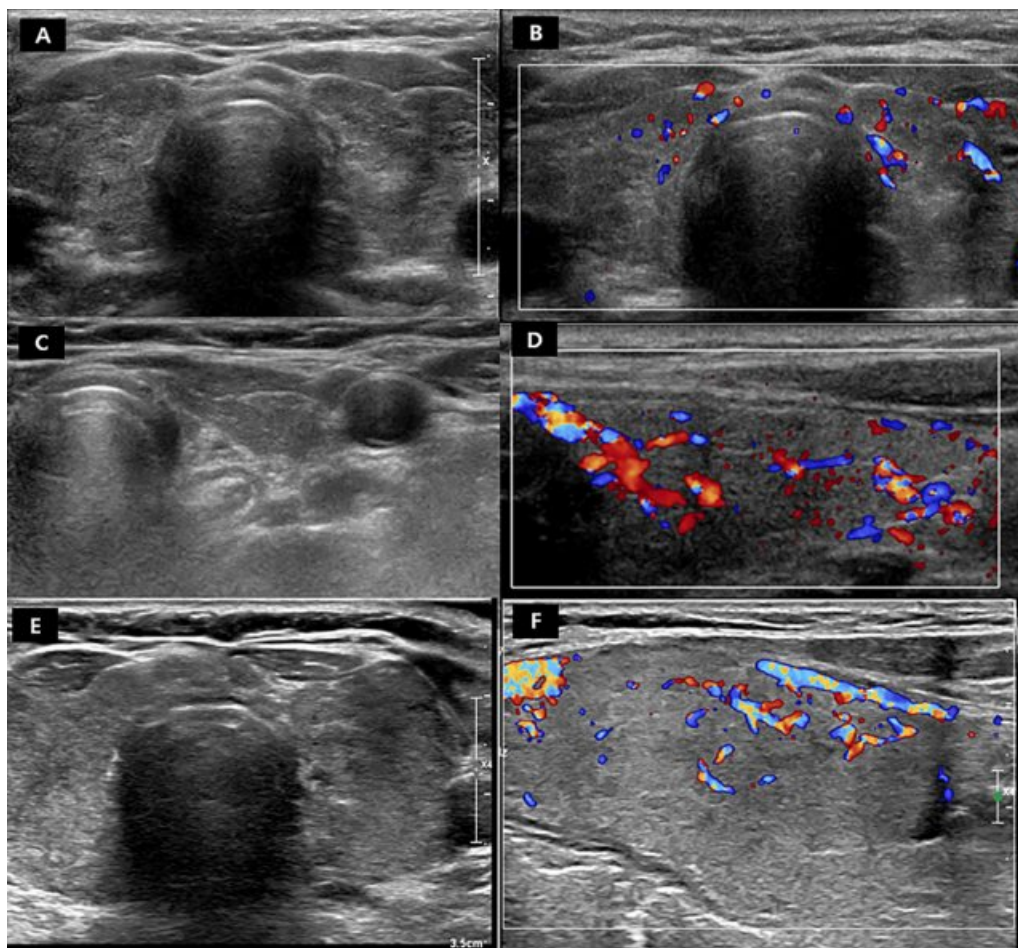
Examples of US features of diffuse thyroid disease (DTD) in three participants. (A, B) US images in a 42-year-old female participant with DTD. (A) Transverse gray-scale image shows heterogeneous coarse echotexture with decreased parenchymal echo and normal anteroposterior diameter. The glandular margin is lobulated. (B) Color Doppler image shows slightly increased vascularity. (C, D) US images in a 63-year-old female participant with DTD. (C) Transverse image shows diffusely decreased parenchymal echo with decreased glandular size. (D) Color Doppler image shows increased vascularity. (E, F) US images in a 35-year-old female participant with DTD. (E) Transverse image shows decreased parenchymal echo with coarse echotexture, increased anteroposterior diameter of the thyroid gland, and lobulated glandular margin. (F) Color Doppler image shows increased parenchymal vascularity.
